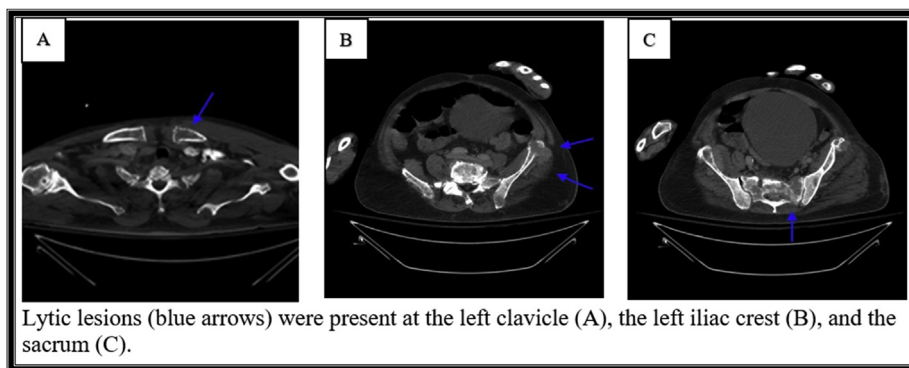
Computed tomography of the chest, abdomen, and pelvis.
